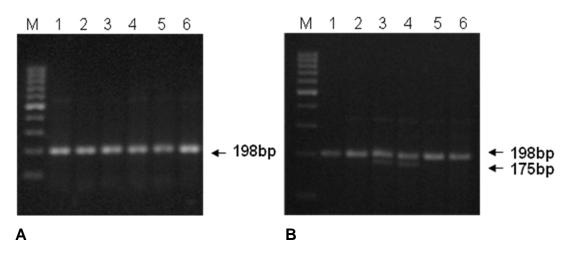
a) The PCR based amplified product of MTHFR C677T gene (198 bp)as shown in figure 1A. RFLP analysis after digestion with *Hinf-I* showing both the genotypes CC homozygous (lane 1, 2, 5 and 6) and CT heterozygous conditions (lane 3, 4) in Figure 1B.
